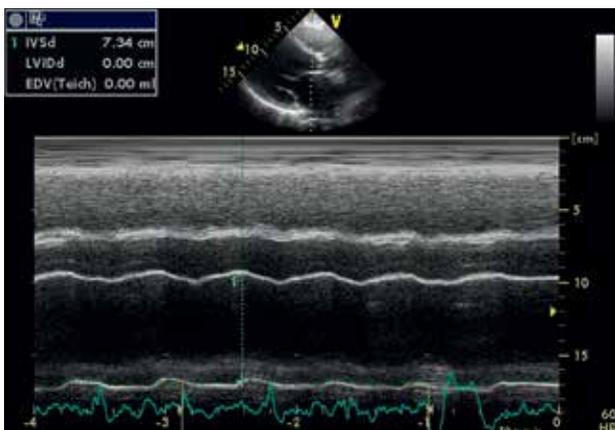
Transthoracic echocardiography. Severe dilatation of a hypocontractile left ventricle and left atrium
